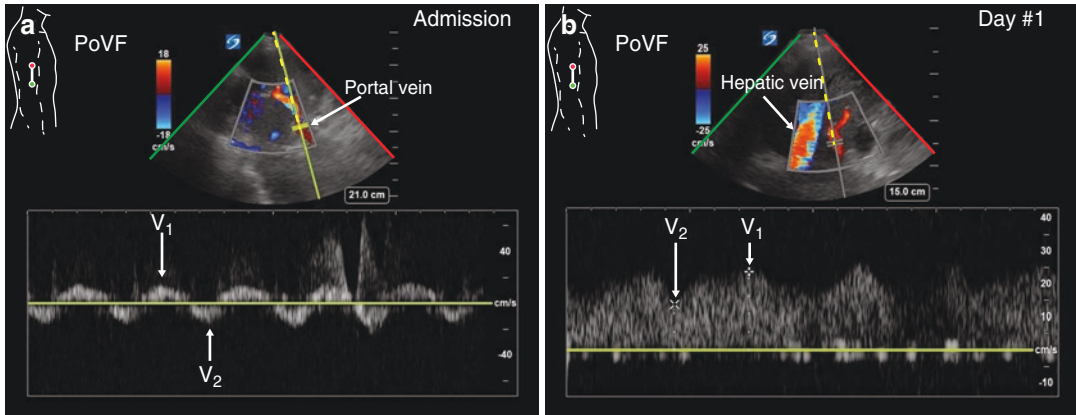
Bedside transthoracic echocardiography upon intensive care unit admission, with posterior axillary line interrogation of the portal vein using spectral Doppler tracing. An abnormal pulsatile portal waveform with transient diastolic flow reversal is seen (V1: peak flow velocity;
